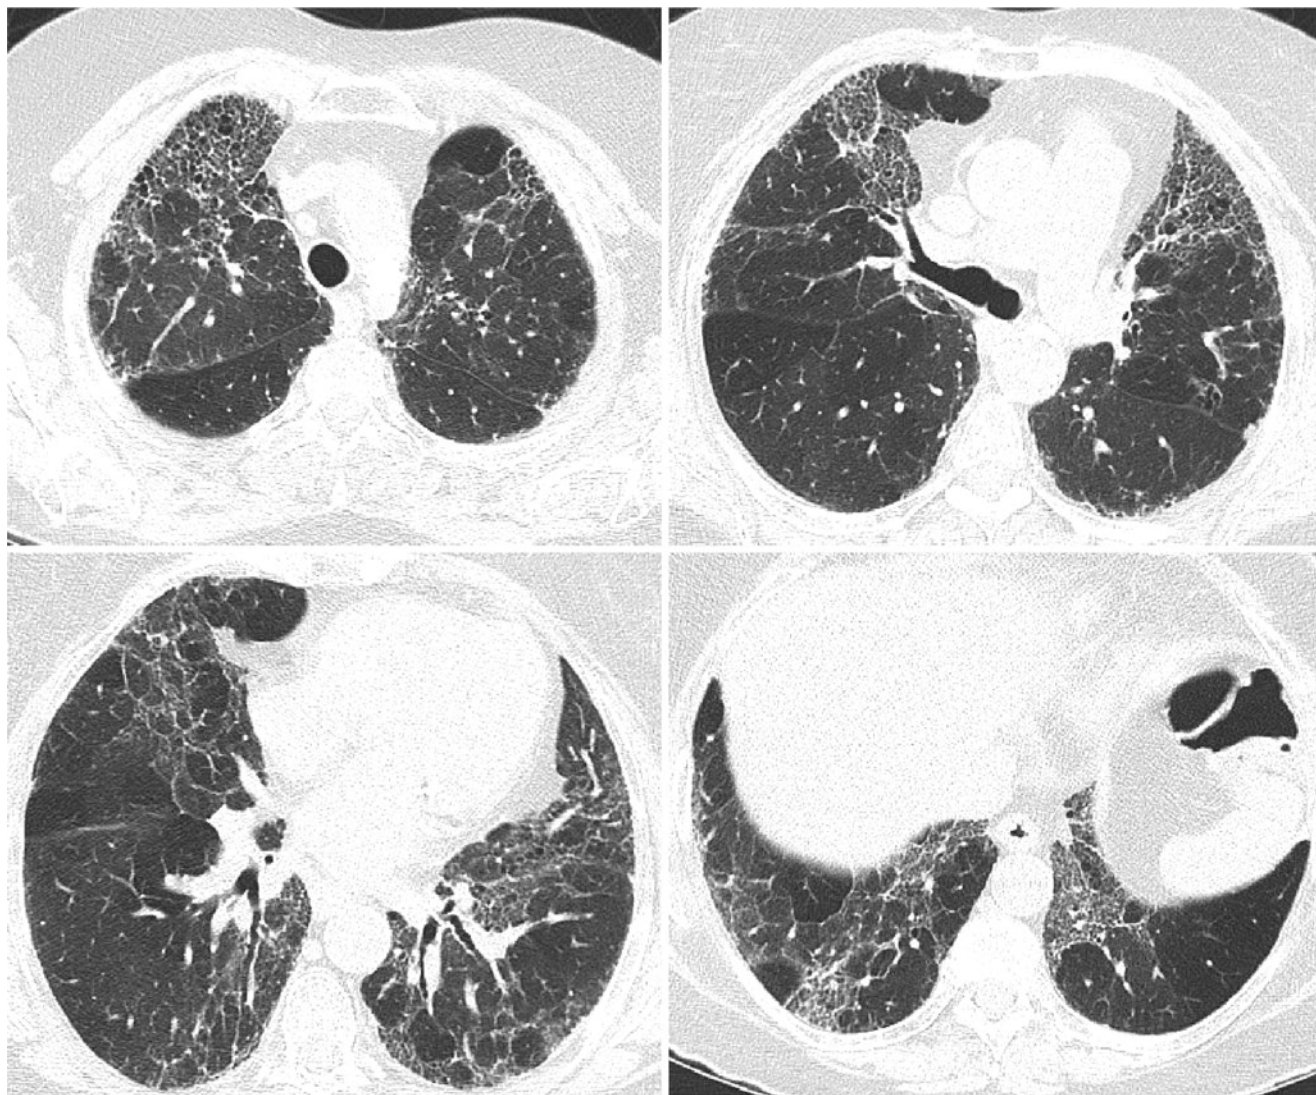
Transaxial chest CT in a patient with exposure to bird antigen showing features of hypersensitivity pneumonitis, including diffuse craniocaudal involvement of ground glass, reticulation, mosaicism, and areas of lobular sparing
